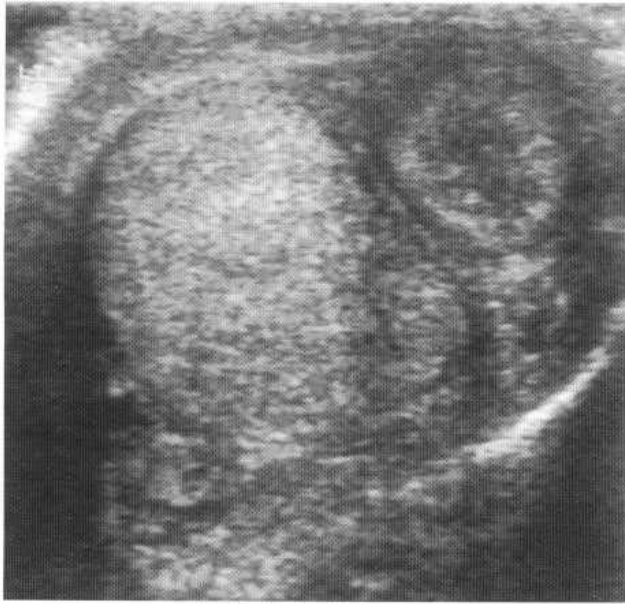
Ultrasound of aggressive epididymitis showing a heterogeneous mass with areas of reduced and increased echogenicity adjacent to the lower pole of the testicle.
